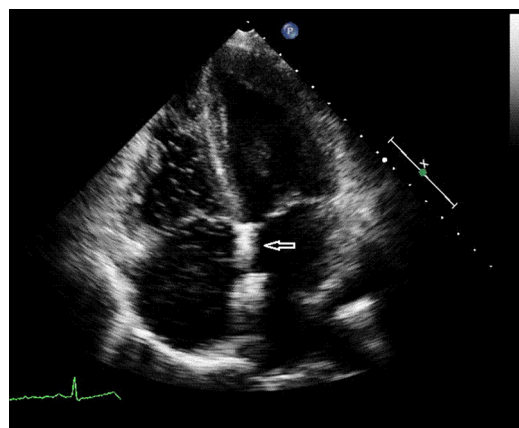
Transthoracic echocardiography: post-dive venous bubbles in right heart chambers in a patient after catheter-based patent foramen ovale closure.
